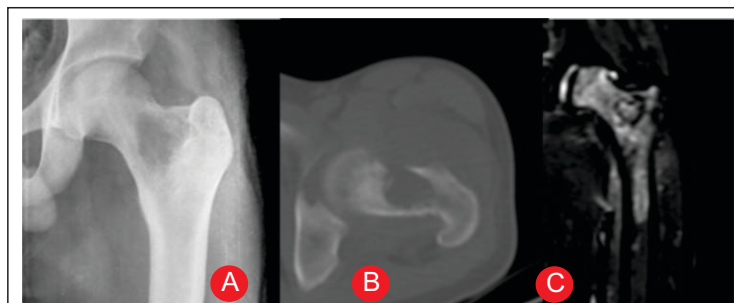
AP (A) radiographs show a lytic lesion with ill defined margins in the proximal femoral metaphysis. (B) Axial CT scan shows cortical break. (C) Large area of altered signal involving the femoral head and proximal femoral metaphyseal region.
